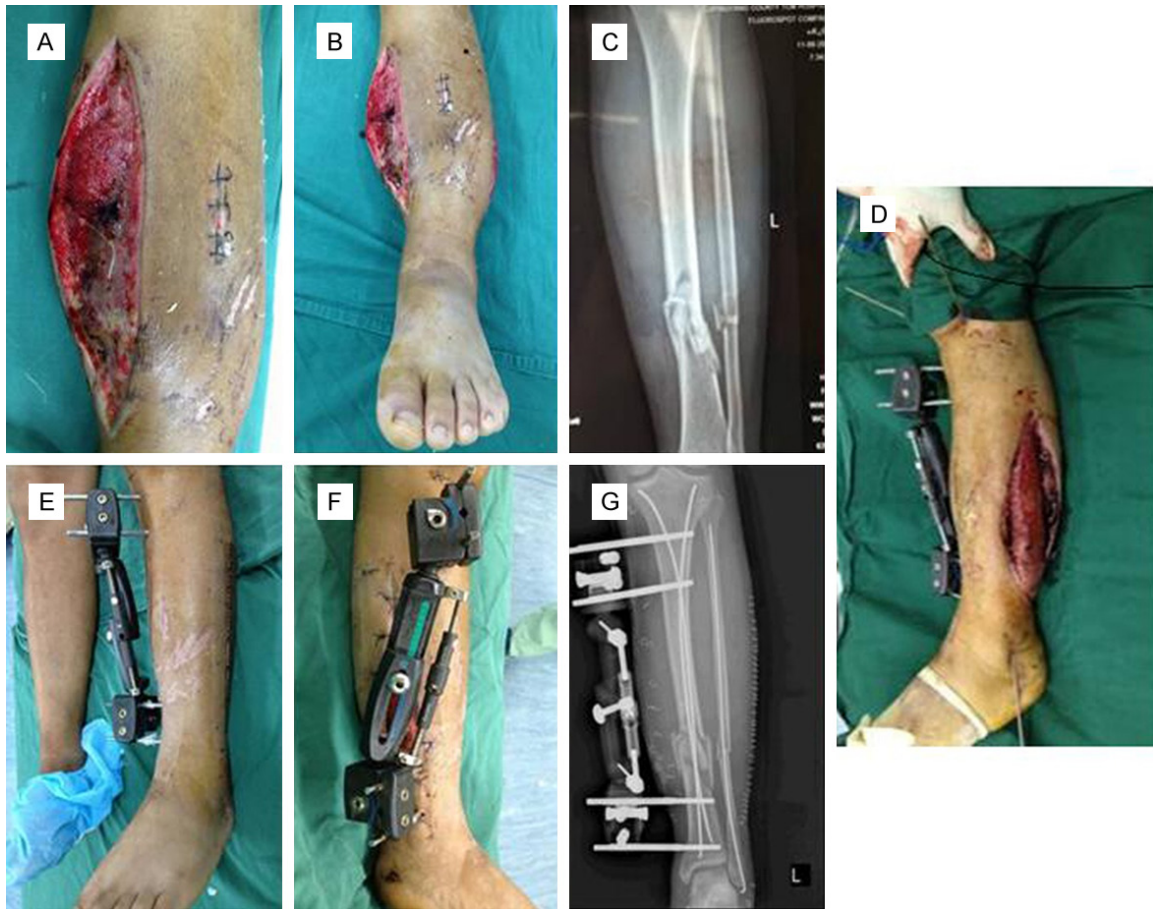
A Gustilo II, 42B fracture occurred osteofascial compartment syndrome with early incision decompression (A-C). The picture presented the fracture was treated with BioEF-TENs system (D). The photos showed that the wound was closed at early stage after dismantling the VSD device (E, F). The postoperative X-ray image of this case (G).
